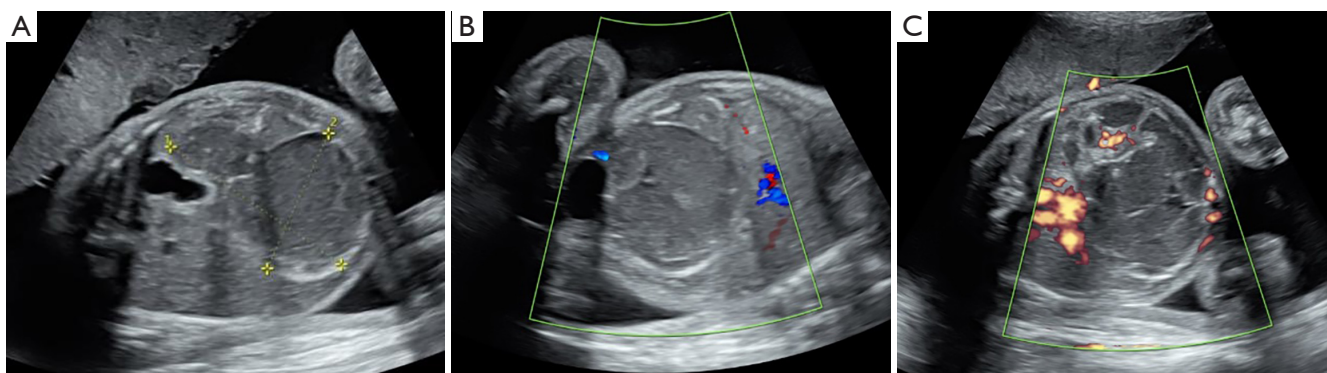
Ultrasound features at 30 weeks of gestation. (A) shows a mass in the abdominal cavity of the fetus. (B) (color Doppler) and (C) (energy Doppler) show the detection of blood flow signals around the abdominal wall (the mass was determined to be a midgut volvulus on follow-up).
